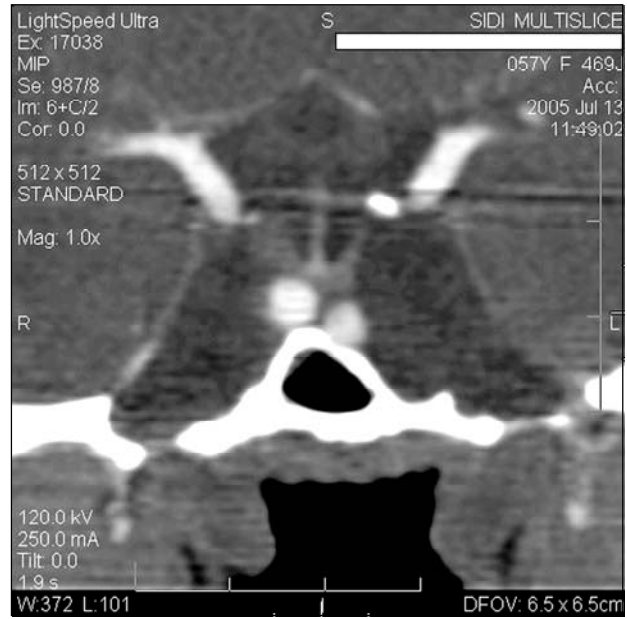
CTA (Coronal View): Intracranial intrasellar kissing carotid arteries.
